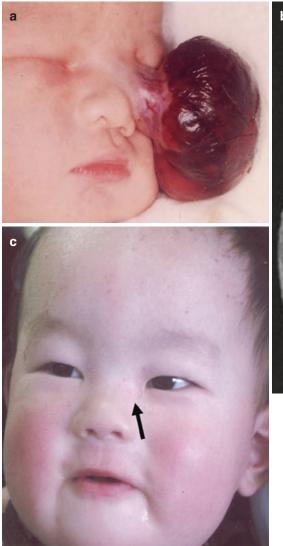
Infantile myofibromatosis, solitary (a) 0-day, boy, A dark red-colored mass ($5 \times 4.5 \times 4$ cm in size) protrudes from the left alar nasal sulcus (b) MRI shows no
